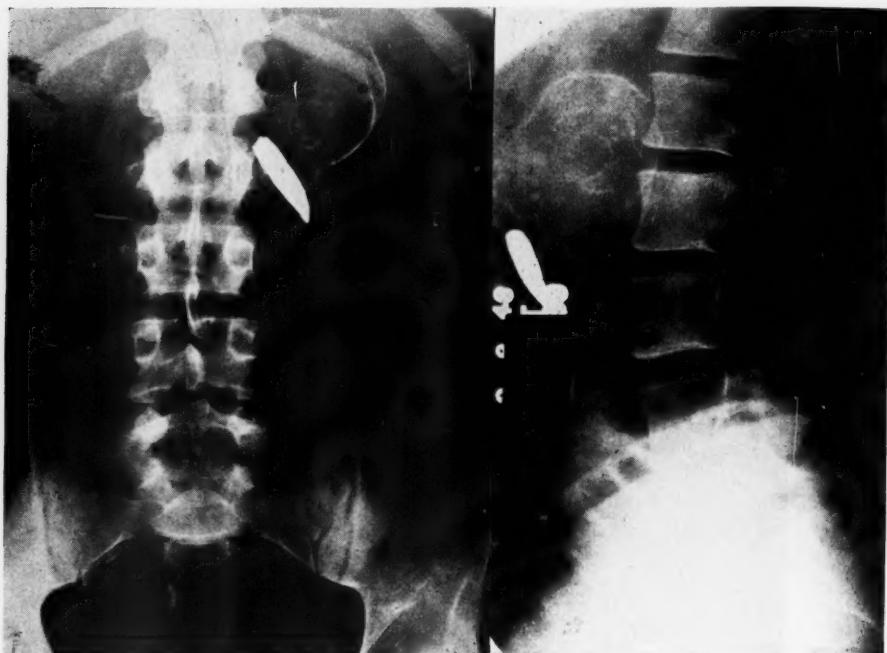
Roentgenograms, anteroposterior and lateral, made July, 1943, showing a soft-tissue mass with a calcified periphery situated to the left of the first and second lumbar vertebrae. The rifle bullet is visible just below the mass.
